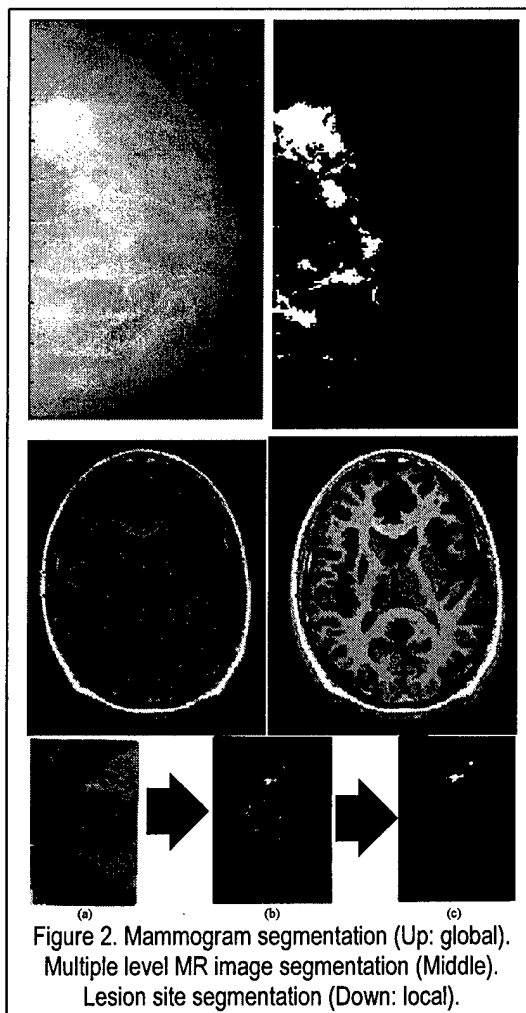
Mammogram segmentation (Up: global). Multiple level MR image segmentation (Middle). Lesion site segmentation (Down: local).
